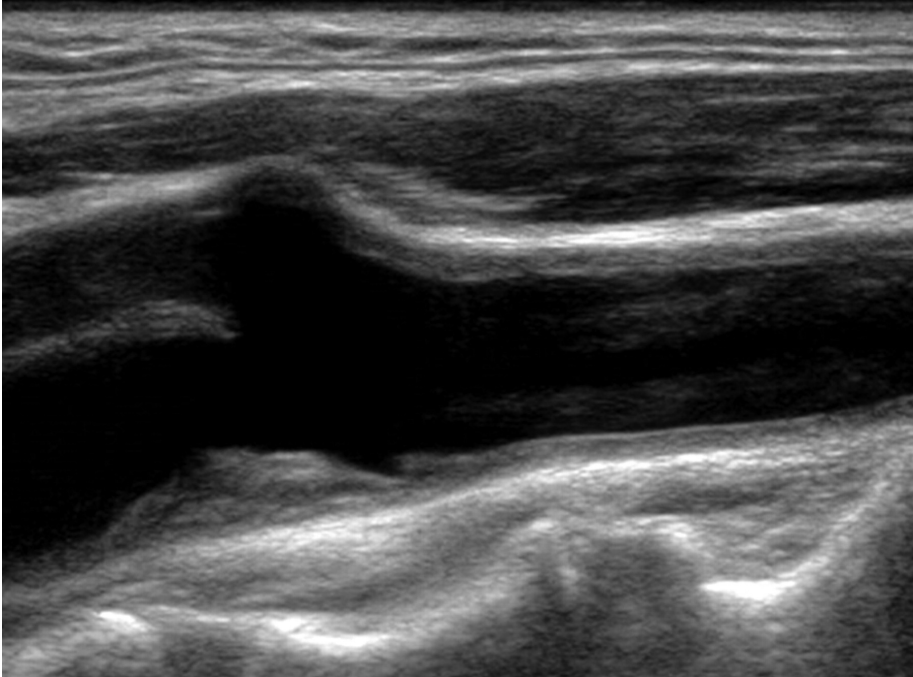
B-mode ultrasound image of carotid artery [22]
